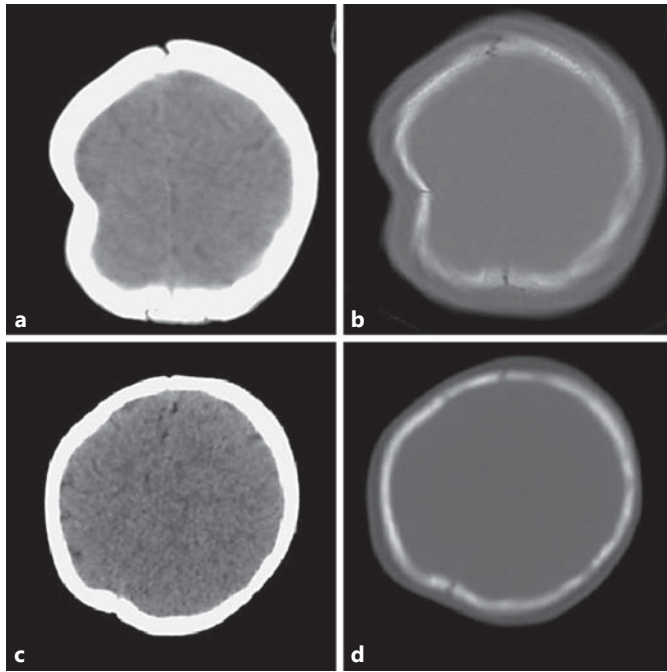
Initial CT of the head revealing a right parietal ping-pong fracture (a, b). Two hours after trauma, a control CT of the head revealed the spontaneous elevation of the ping-pong fracture (c, d).
